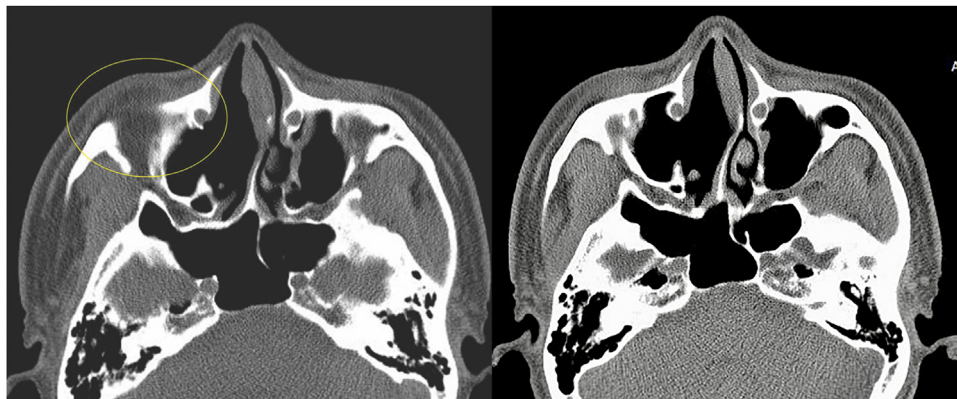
The computed tomography (CT) demonstrated subcutaneous cystic mass lesion on right lower eyelid lesion measuring about 1 cm (Circle, Left). Definite fracture such as blow out fracture or empyema was not identified at this stage and endoscopic sinus surgery was proved by this image. Post endoscopic sinus surgery CT showed large antrostomy with undamaged nasolacrimal duct (Right).
